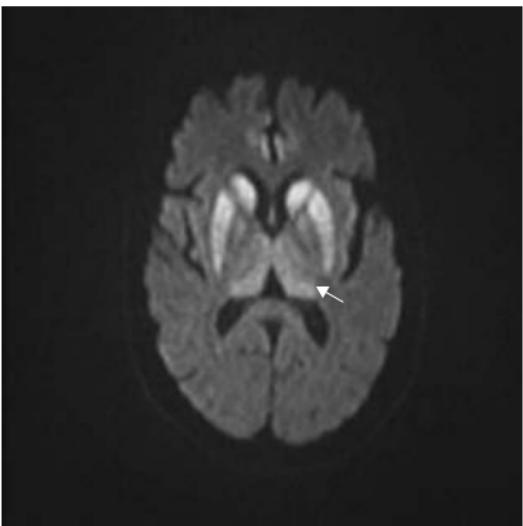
Sporadic Creutzfeldt–Jakob disease (sCJD). (a) FLAIR axial and (b) diffusion-weighted (DWI) MRI. Bilateral symmetric hyperintensity involving the striatal nuclei (black arrows). With less prominent involvement of the pulvinar and medial nuclei of the thalamus bilaterally (open black arrowheads). (b) Note the more conspicuous signal change and increased sensitivity on DWI. In contrast, variant CJD (vCJD) typically demonstrates marked hyperintensity in the pulvinar and medial nuclei of the thalamus bilaterally as the most prominent feature (the so-called ‘hockey-stick’ sign, white arrow).
